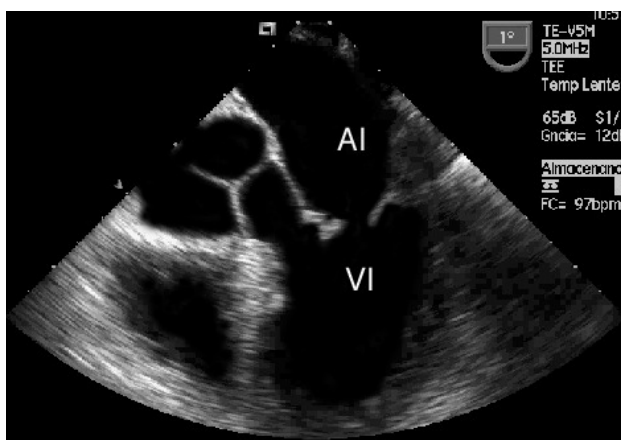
Transesophageal echocardiography in a patient with the primary antiphospholipid syndrome. There is slight thickening of the free edge of the anterior mitral leaflet. LA indicates left atrium; LV, left ventricle.
